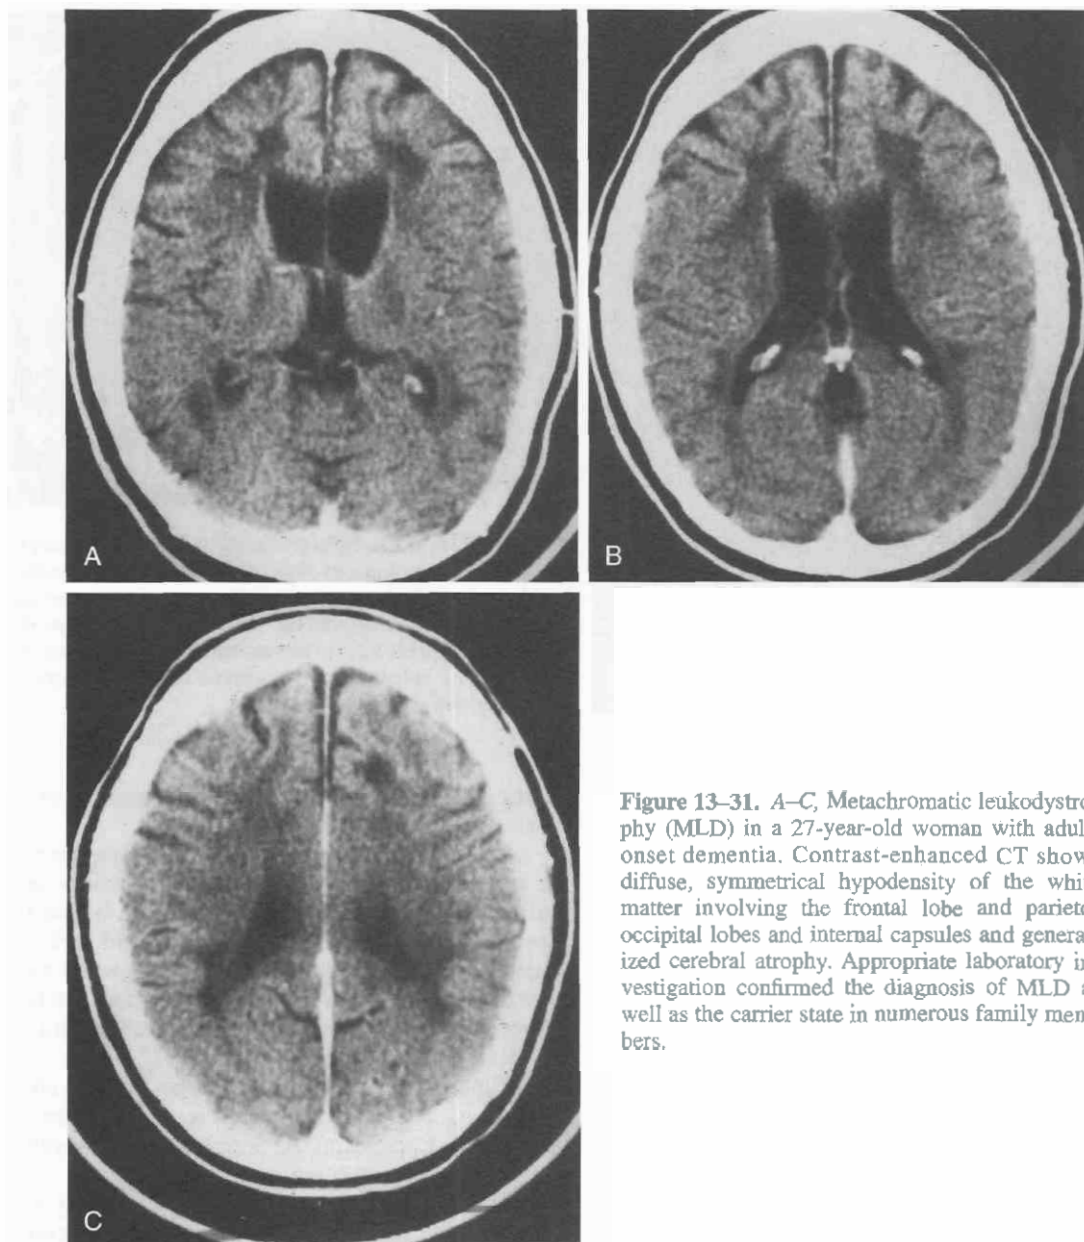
A–C, Metachromatic leukodystrophy (MLD) in a 27-year-old woman with adult-onset dementia. Contrast-enhanced CT shows diffuse, symmetrical hypodensity of the white matter involving the frontal lobe and parieto-occipital lobes and internal capsules and generalized cerebral atrophy. Appropriate laboratory investigation confirmed the diagnosis of MLD as well as the carrier state in numerous family members.
